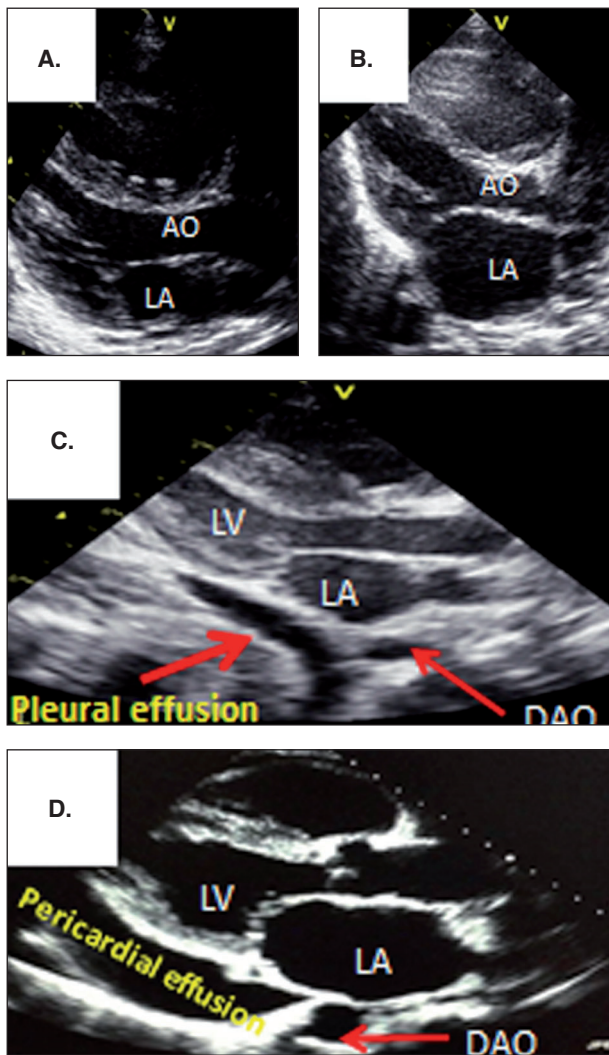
Long axis parasternal view with normal LA size in image A, and dilated due to PDA in image B. Image C shows mild pleural effusion outside the pericardial sac and passing posterior to the cross section of DAO; it should be differentiated from pericardial effusion in image D with fluid within the pericardial sac and passing anterior to the cross section of the DAO.
